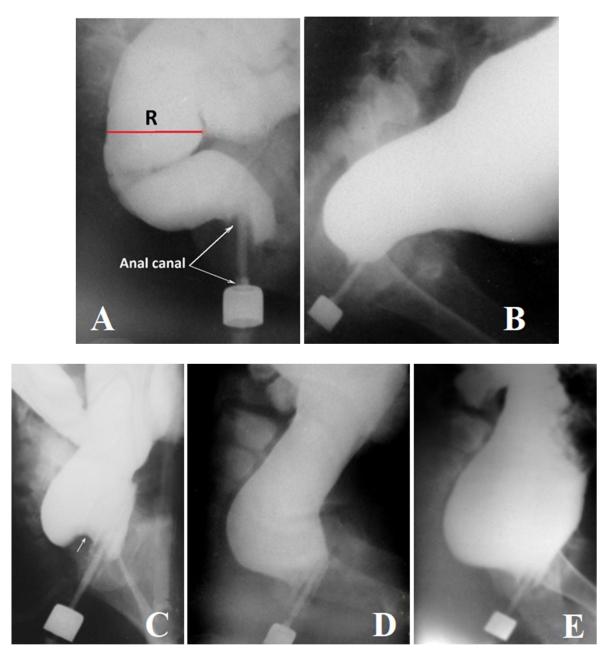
Lateral x-ray images of the anorectal zone. (A) In a healthy child, the rectum of normal width has vertical and horizontal branches. As a result of IAS relaxation, barium penetrated the upper part of the anal canal in front of the enema tip. The posterior wall of the anal canal is pressed to the tip as a result of the PRM contraction. The axis of the anal canal is shifted forward relative to the axis of the rectum. (B) Patient with Hirschsprung disease. Due to the absence of ganglia in the rectum, there is no neural connection between the rectal wall and PRM. As a result of this, PRM is not contracted and is not relaxed. Therefore, the rectum is represented only by the vertical branch. The aganglionic rectum has a normal
